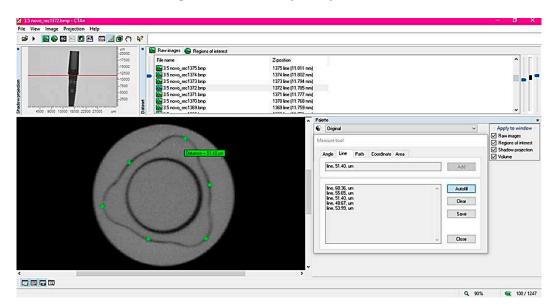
Representation of linear (two-dimensional) analysis in CT analysis. The reconstructed image (upper left corner) was fixed in the region of interest (ROI) and 10 sections were selected in that region for six measurements (asterisks) on the tri-channel platform.
